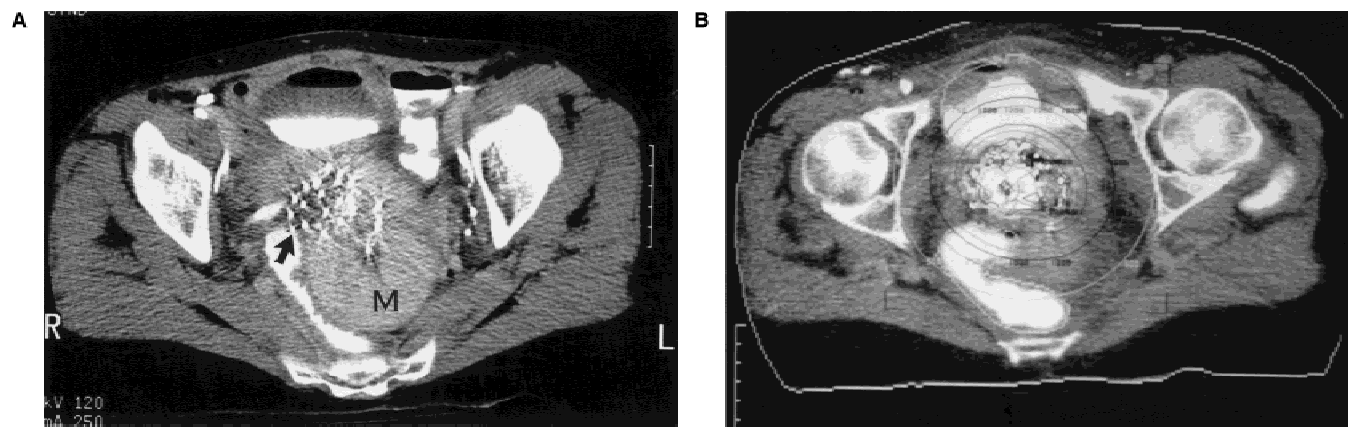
A: Axial CT demonstrating circuitous rectosigmoid distinguished with contrast. Note: needle (arrow) in close proximity to rectum which was not loaded. Note: Large uterine myoma which is not traversed by needles (M). B: Same patient, lower axial level with dose distribution superimposed on the axial CT. Note: Contrast-defined bladder and rectum intersected by the isodose distribution. This enables direct visualization of the dose distribution throughout the tumor volume, bladder, and rectum. (Reprinted with permission from Erickson B, Albano K, Gillin M: CT guided interstitial implantation of gynecologic malignancies. *International Journal of Radiation Oncology • Biology • Physics* 1996; 36:699–709. Elsevier Science Inc.)
